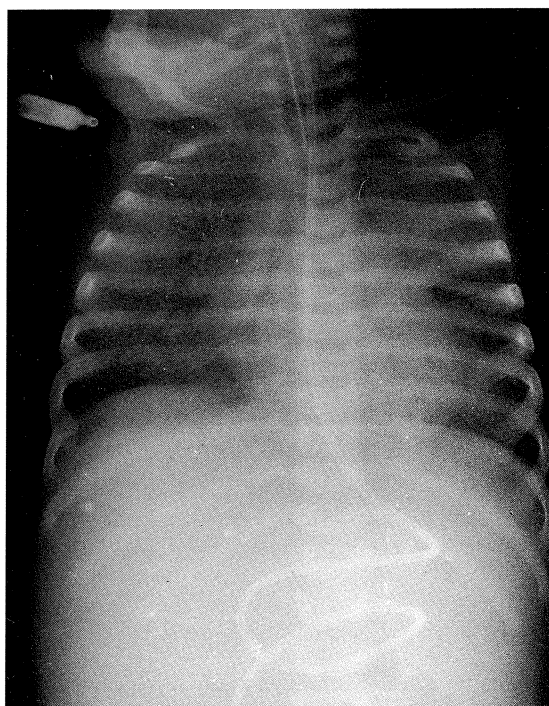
Repeat chest radiograph.
